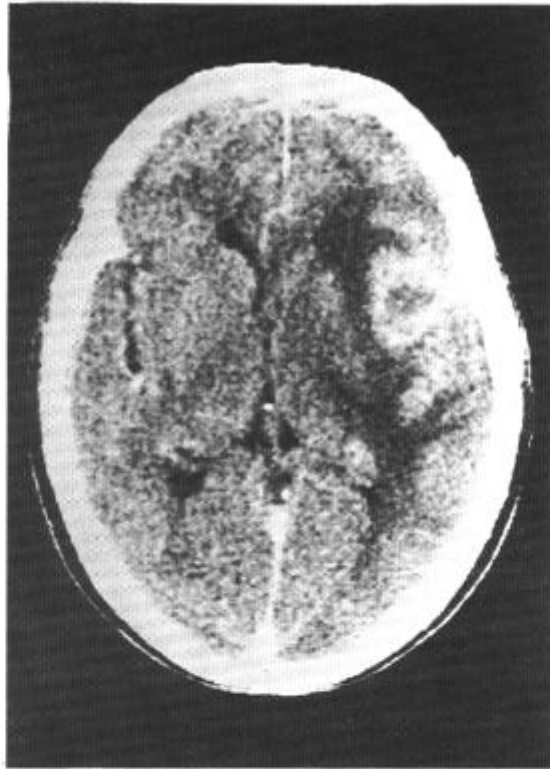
A CT scan of case 10 revealed an enhanced tumor with a surrounding low density area in the right fronto-temporal region.
